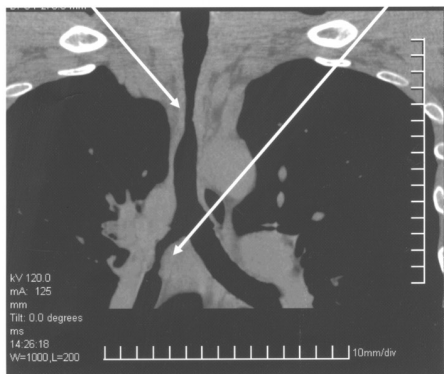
Bronchoscopy and coronal CT scan demonstrating tracheal and right main bronchus stenosis
